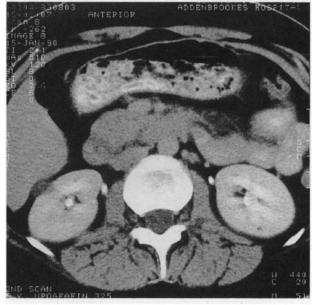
Abdominal CT scan showing renal and pancreatic cysts.
